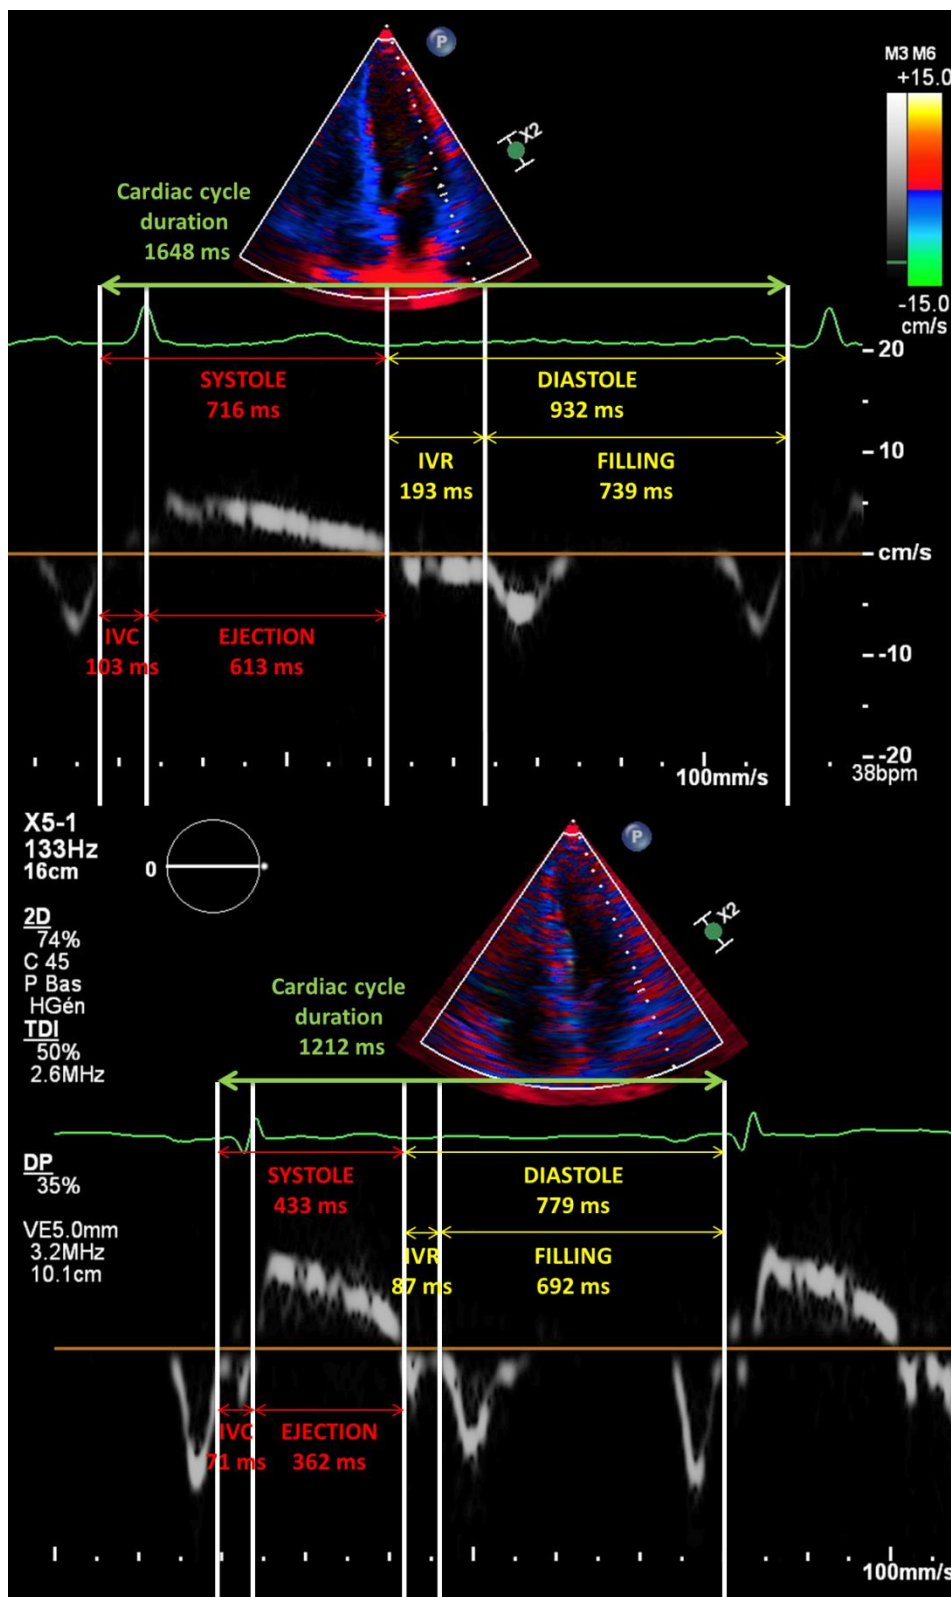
Comparison of tissue Doppler imaging at lateral mitral annulus in the same patient in hypothermia (at the top) and in normothermia (below). IVC: isovolumic contraction time, IVR: isovolumic relaxation time.
